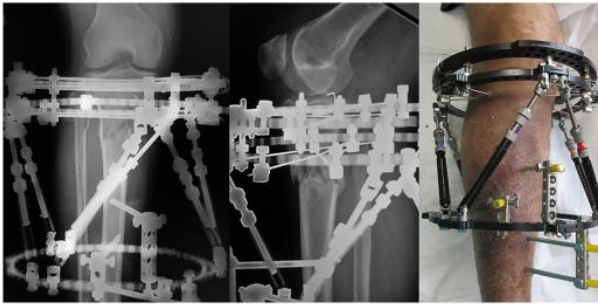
The final result of HCEF both clinically and from the radiograph.²
